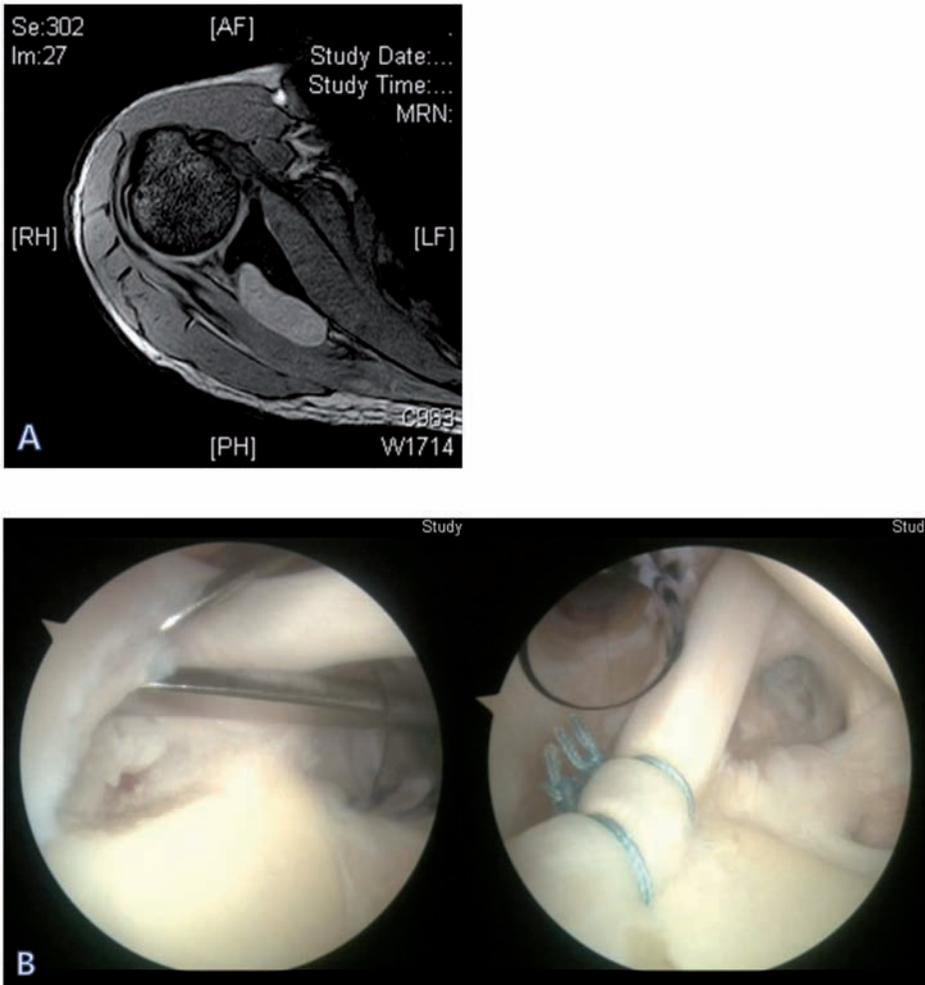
A. MRI T2WI shows ganglion cyst formation at the spinoglenoid notch. B. After ganglion cyst decompression (B-1), arthroscopic SLAP repair is performed (B-2).
